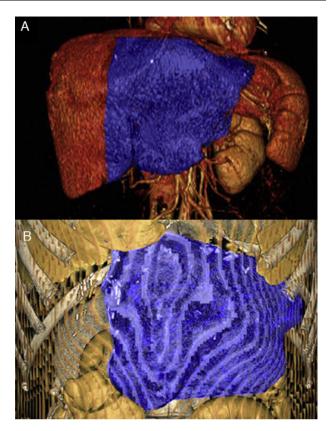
(A) Preoperative liver volumetric CT at 492 ml. (B) Volume at 690 ml on the  $6^{\rm th}$  day following the procedure.
